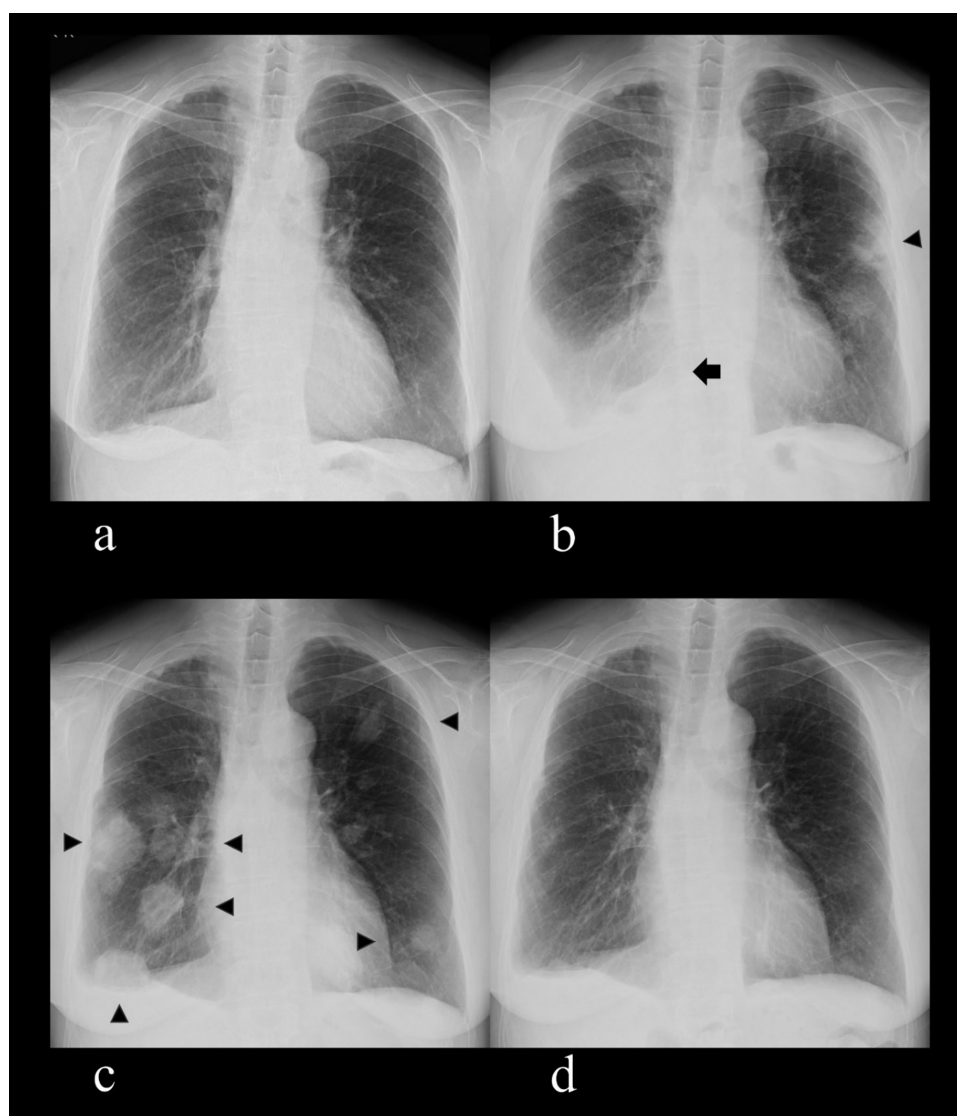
Changes in chest X-rays of Patient 2. (a) Slight blunting of the costophrenic angles in the right lung at the time of the first visit to our hospital. (b) Worsening of right pleural effusion (arrow) and multiple shadows in the left lung (arrowhead) due to inflammation of rheumatoid arthritis. (c) Multiple nodules in both lungs at the diagnosis of LPD (arrowheads). (d) The nodules disappeared 5 months after discontinuation of MTX.
